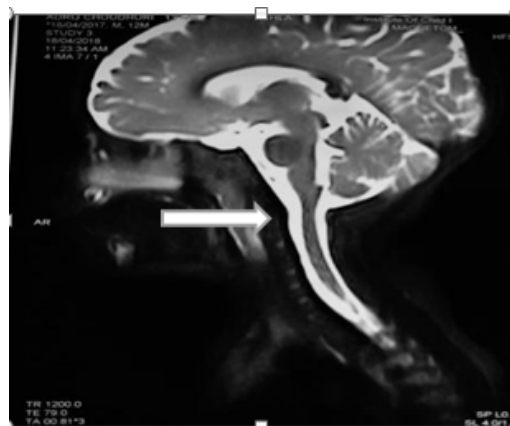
MRI of neck showing retropharyngeal edema, cellulitis and phlegmon.
